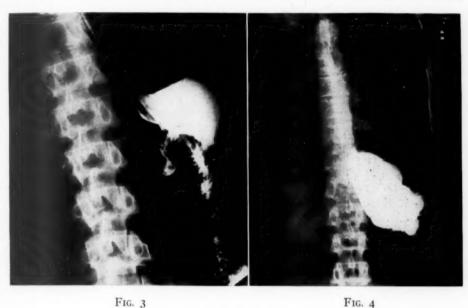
(Case 1) Postoperative roentgen ray of stomach showing a well functioning gastro-enterostomy and no evidence of esophageal stricture.
